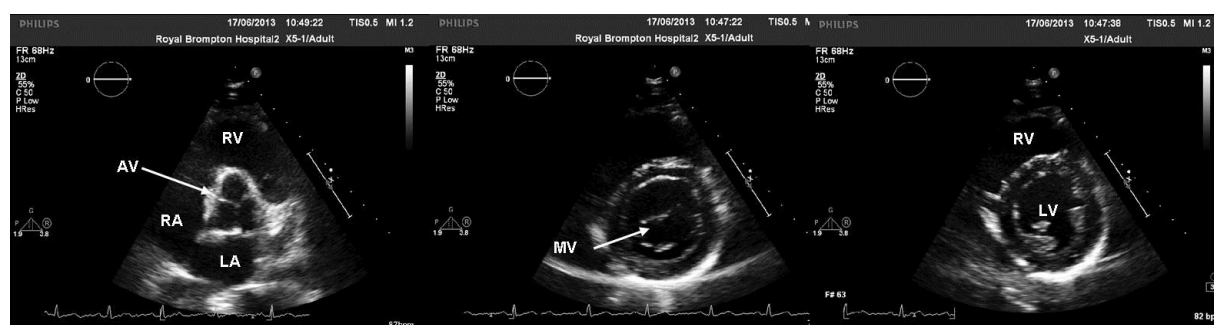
Parasternal short axis views showing the effect of tilting the ultrasound beam.. On the image to the left the US beam has been tilted superiorly, demonstrating the aortic valve (AV) which is seen at the centre of the heart. In the central image the US beam has been tilted inferiorly to show the leaflets of the mitral valve in the centre of the circular LV. In the image on the right, the US beam is tilted more inferiorly, bringing the papillary muscles into view. This is the optimal parasternal short-axis view for imaging the LV.
